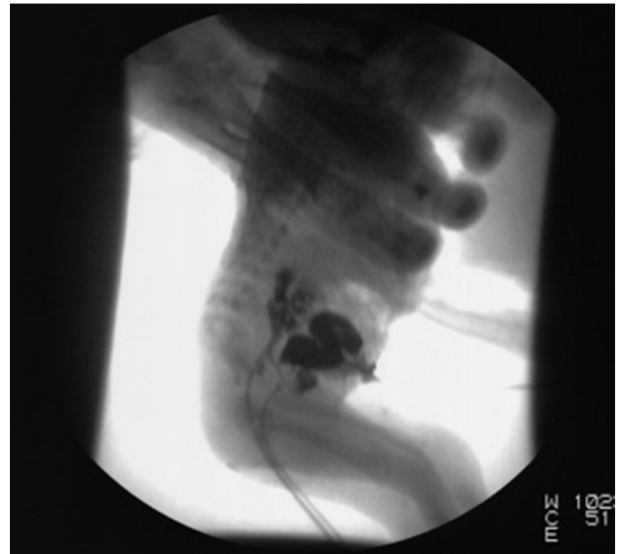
X-ray image of “double perineal catheterization” with catheters in situ in bladder and vagina.
